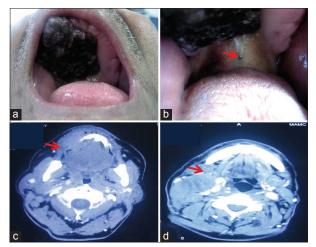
(a) Blackish brown proliferative growth on edentulous maxillary arch and palate and (b) small blackish macules on the soft palate. Contrast enhanced computed tomography showing (c) a large infiltrating homogenous mass on right anterior alveolus. (d) heterogenous enlarged submandibular lymph nodes
